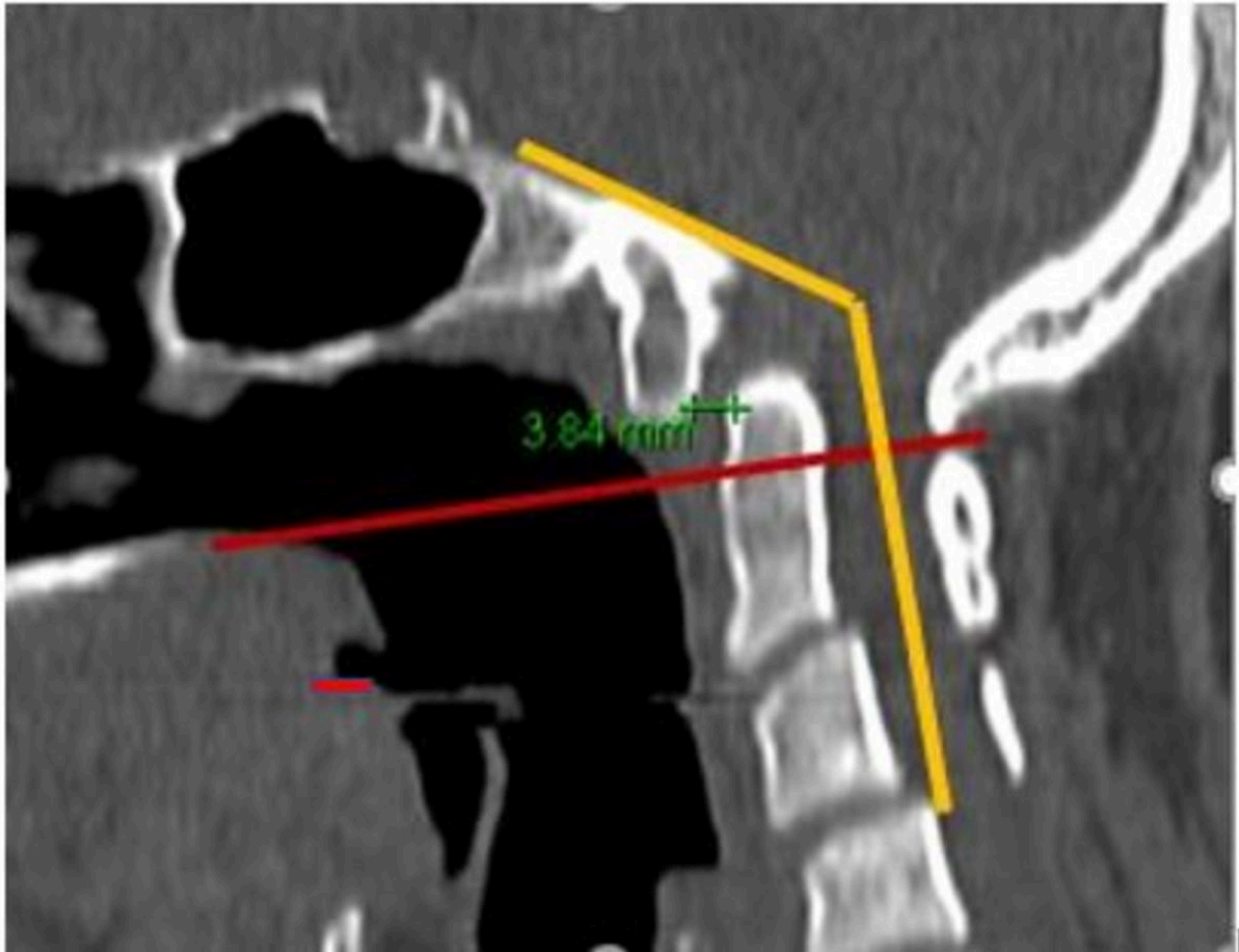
CT saggital section showing voilation of chamberlain's line(red) and atlantoaxial dislocation(atlantodens interval -3.8mm).Dens projecting 6mm above chamberlains line is diagnostic of basilar invagination
